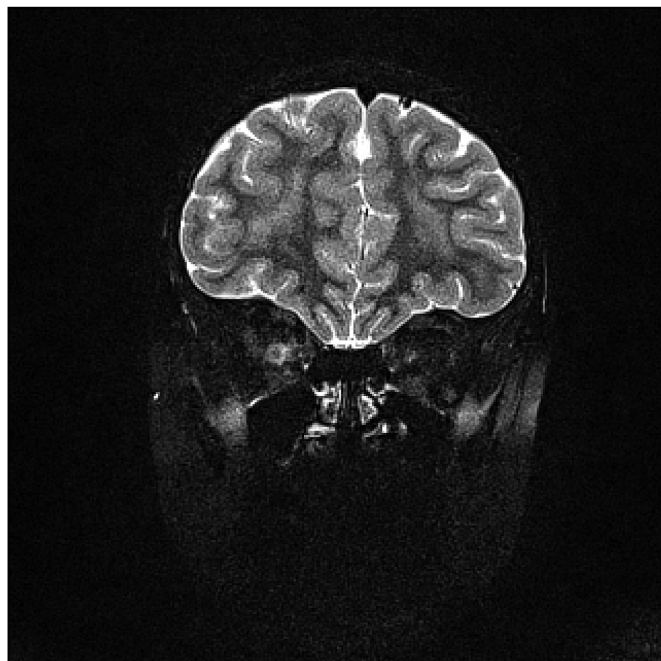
T2 MRI with fat suppression, coronal view. Attention to area of enhancement of the right optic nerve.
